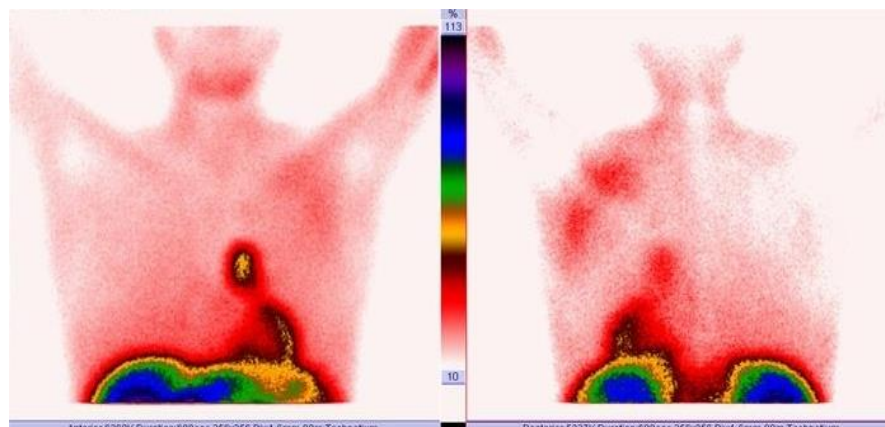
Thymic scintigraphy
